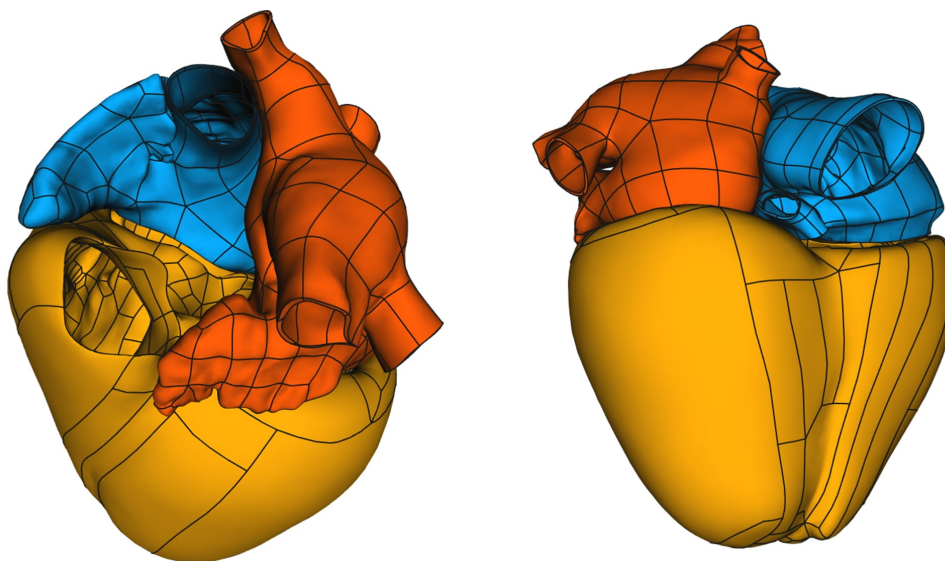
The Zygote heart CAD model [107] reconstructed from high-resolution CT-scan, representing an average healthy heart. Image taken from [37].
